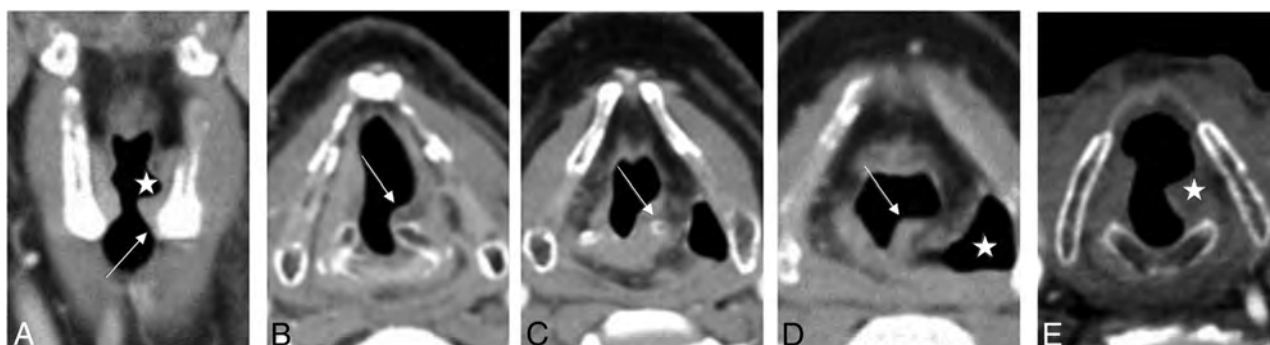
CT findings of UVFP images from 2 patients with proven left UVFP. *A*, Coronal CT image demonstrates dilation of the left laryngeal ventricle (*star*) and loss of the subglottic arch (*arrow*). *B*, Axial CT image demonstrates medial positioning of the left posterior vocal fold margin (*arrow*). *C*, Axial CT image demonstrates anterior positioning of the left arytenoid cartilage (*arrow*). *D*, Axial CT image demonstrates rotation and thickening of the left aryepiglottic fold and enlargement of the left pyriform sinus (*star*). *E*, Axial CT image demonstrates the mushroom sign, tilting toward the left (*star*).
